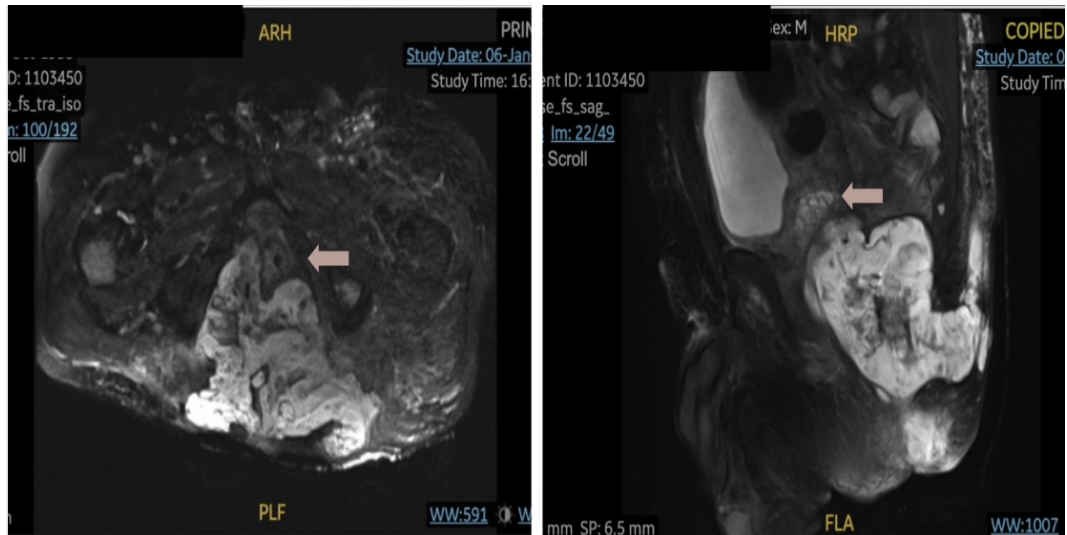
Axial and sagittal view magnetic resonance imaging of pelvis showed circumferential low rectal wall thickening with multiloculated collection and pelvis lymphadenopathy.
